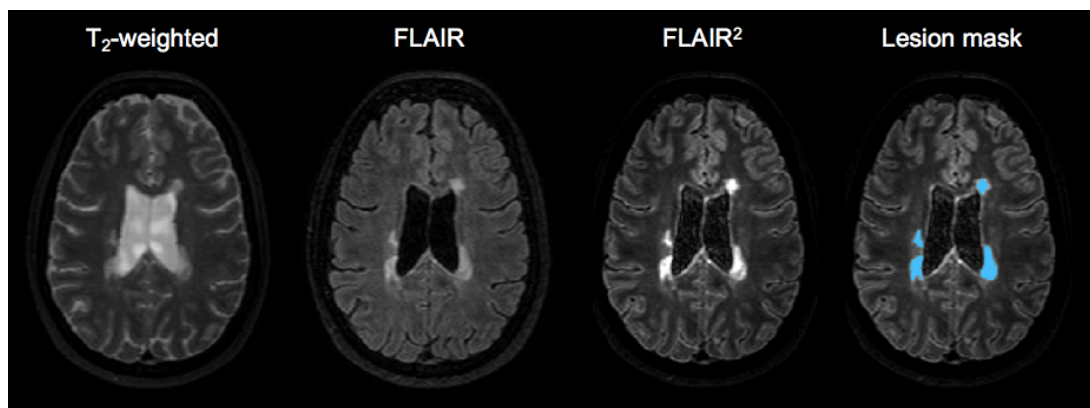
Example of FLAIR² image for lesion segmentation for a subject with periventricular lesions. From left to right: T_2 -weighted, FLAIR, FLAIR² image, and overlaid lesion mask in blue. This subject (52 years old, female, aquaporin-4 antibody negative, disease duration 6 years, EDSS 2.5) presents with several T_2 -hyperintense periventricular lesions and has a lesion load of 4104.19 mm³ (4.10 millilitres).
